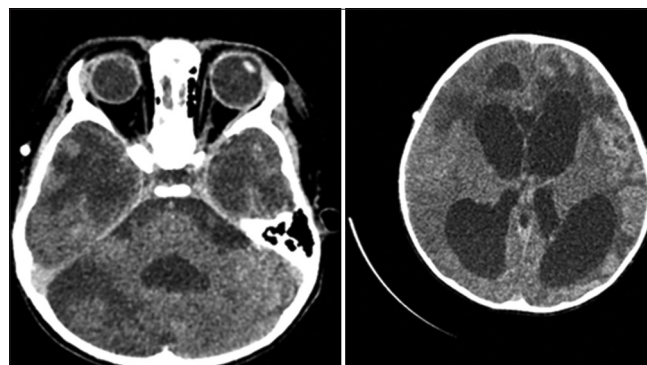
Second Head CT scan: Suspected lesion on the cerebellum
